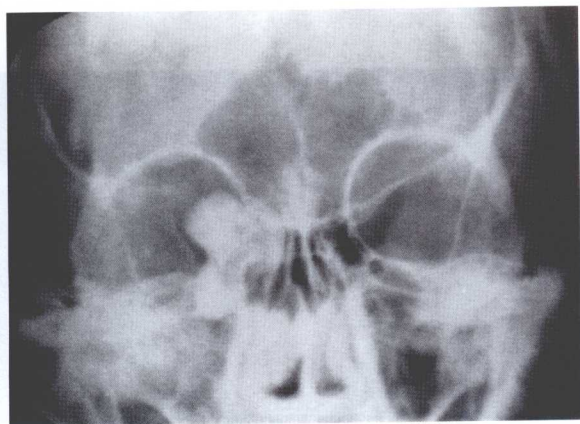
Radiograph showing an osteoma on the nasal side of the orbit giving rise to proptosis.
